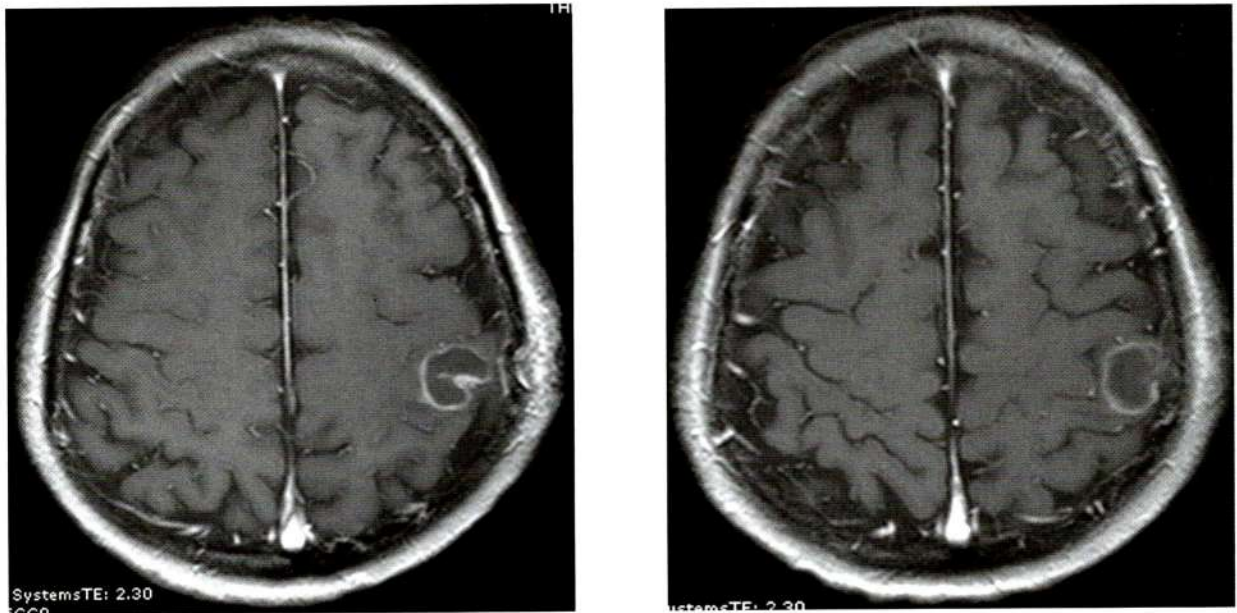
6-months follow up axial enhanced T1W MRI of the brain showed decreased size of the rim-enhanced lesion without perilesional edema.
